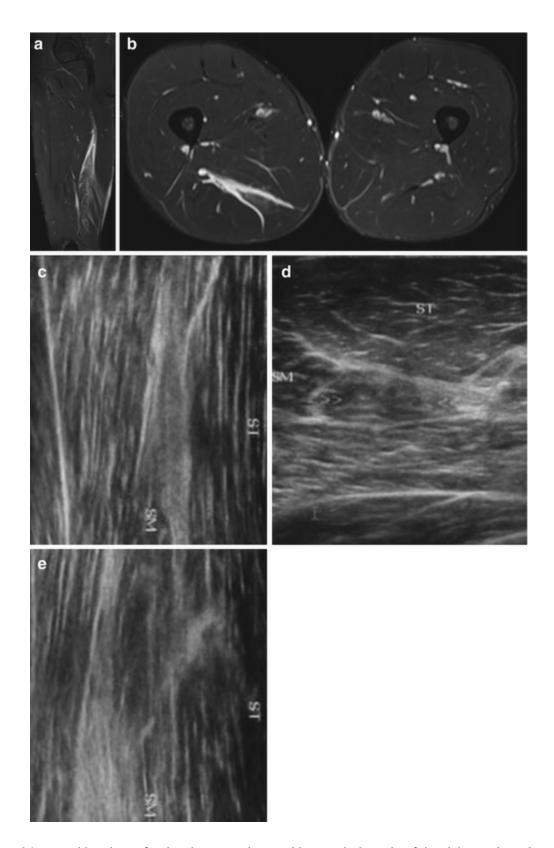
A 34-year-old male professional soccer player with a grade 2 strain of the right semimembranosus muscle. Sagittal (a) and axial (b) STIR MRI show irregularity of the proximal myotendinous junction of the semimembranosus and intermuscular fluid. Corresponding sagittal (c) and axial (d) ultrasound images depict a hyperechoic semimembranosus muscle with myofibrillar disruption. Sagittal ultrasound image (e) shows the 20-gauge needle in place for ultrasound-guided injection of platelet-rich plasma
